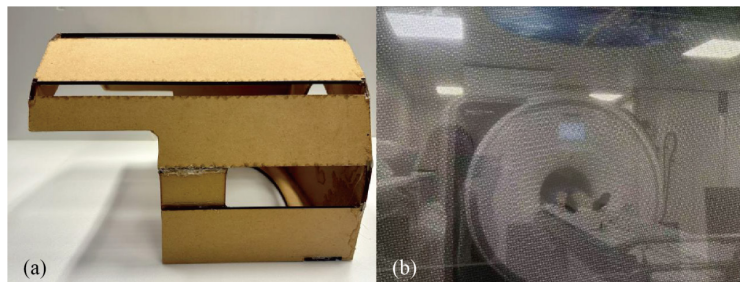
(a) The wooden coil holder used in the MRI scan to hold the body coil; (b) The subject is undergoing MRI scanning.
